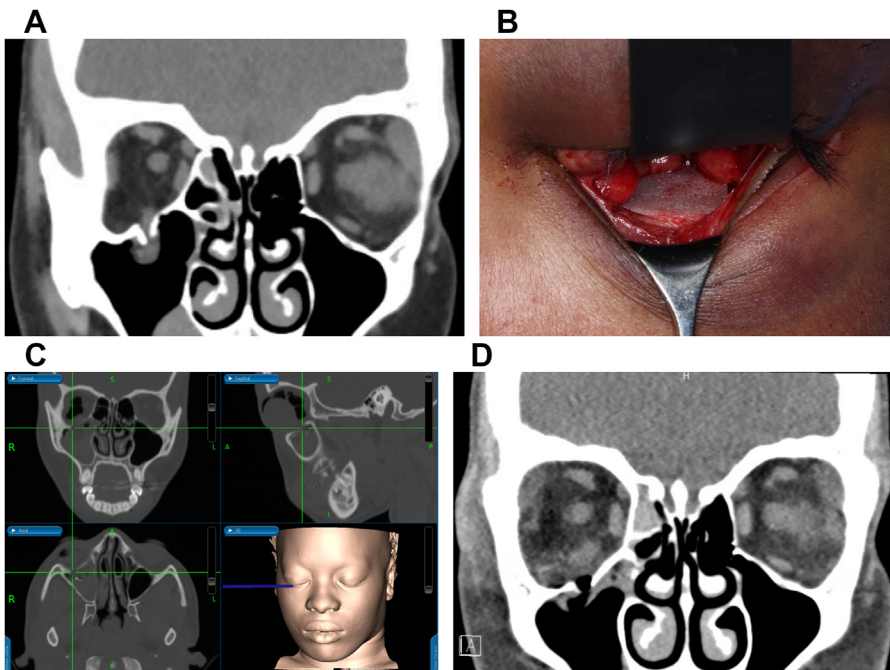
Case of an isolated orbital floor fracture in a 14-year-old patient presenting with extraocular muscle entrapment. (A) CT coronal view demonstrating herniation of the inferior rectus into the right maxillary sinus, of note entrapment cannot be diagnosed radiographically and requires a clinical examination for confirmation. (B) Orbital floor reconstruction with a porous polyethylene implant placed through a transconjunctival approach without screw fixation. (C) Intraoperative navigation used to confirm the posterolateral seating of the orbital implant. (D) Postoperative imaging demonstrating reduced orbital contents. Porous polyethylene implants are radiolucent and therefore they are not visible on CT scans.
